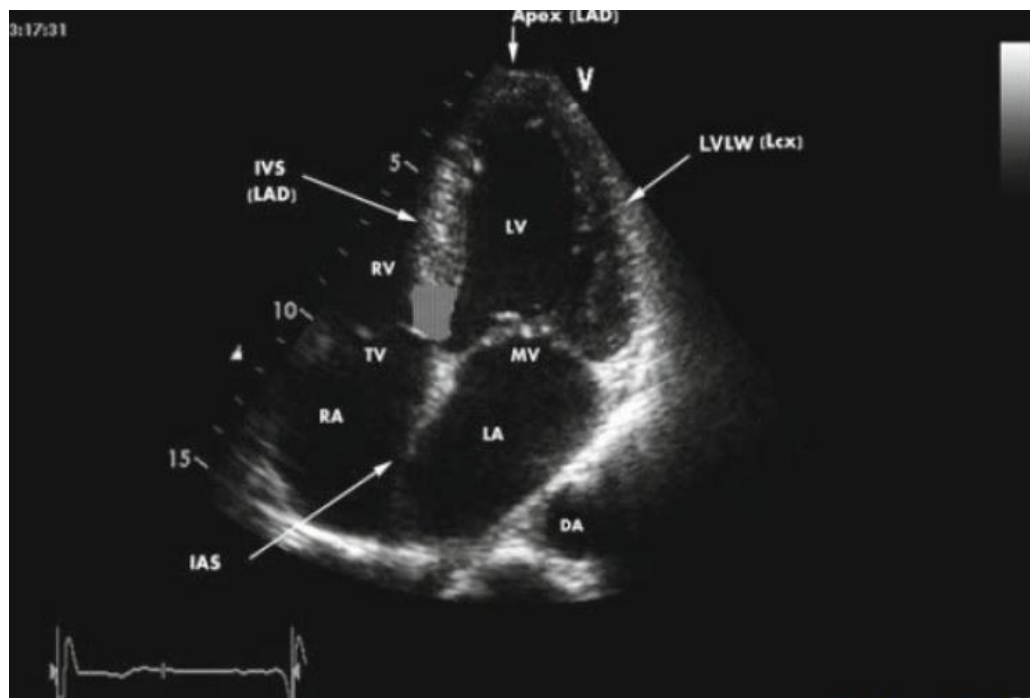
Echocardiographic picture of the heart
